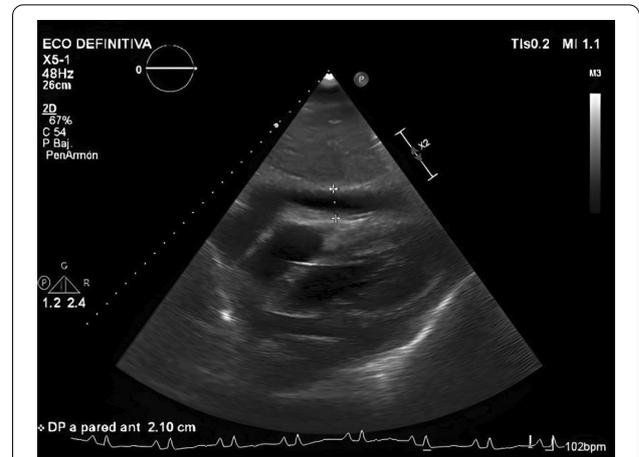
Transthoracic echocardiography showing a massive pericardial effusion
